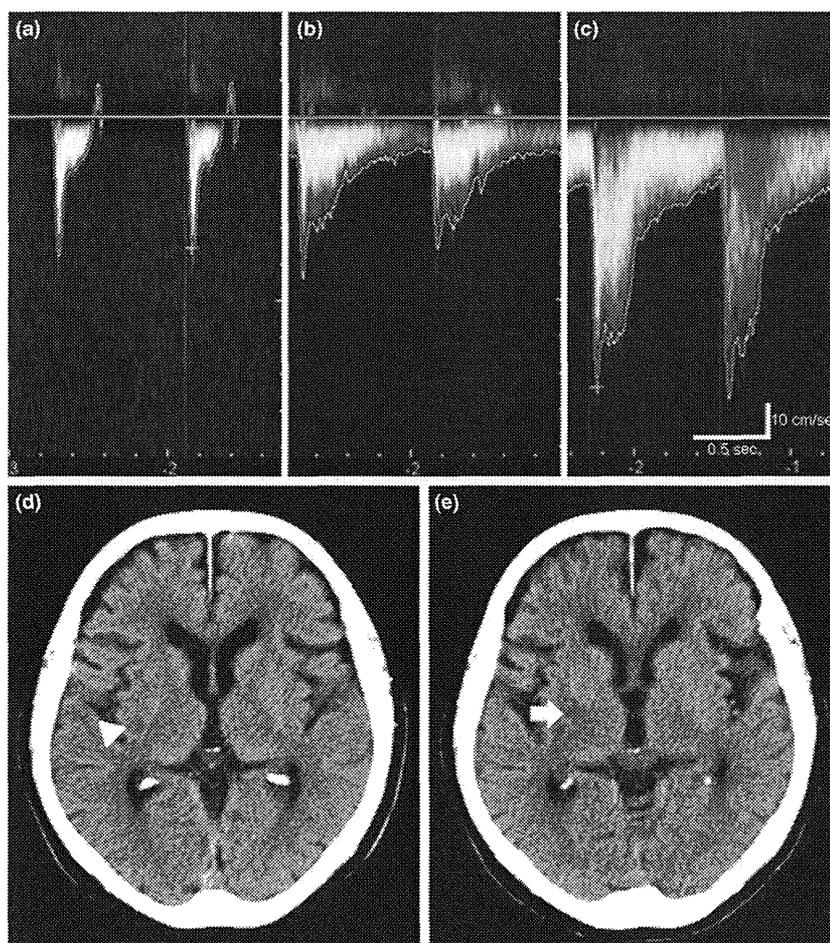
Pulse Doppler findings of the right internal carotid artery. (a) The absence of end diastolic flow on admission. (b) Appearance of end diastolic flow 30 min after starting intravenous thrombolysis. (c) Normalization of blood flow velocity 24 h after starting intravenous thrombolysis; computed tomography of the head. (d) An ambiguous finding of right putamen hypodensity is shown by an arrowhead shortly after recurrent ischemic stroke. (e) A hypodense area is shown by an arrow in the right putamen on hospital day 14.
